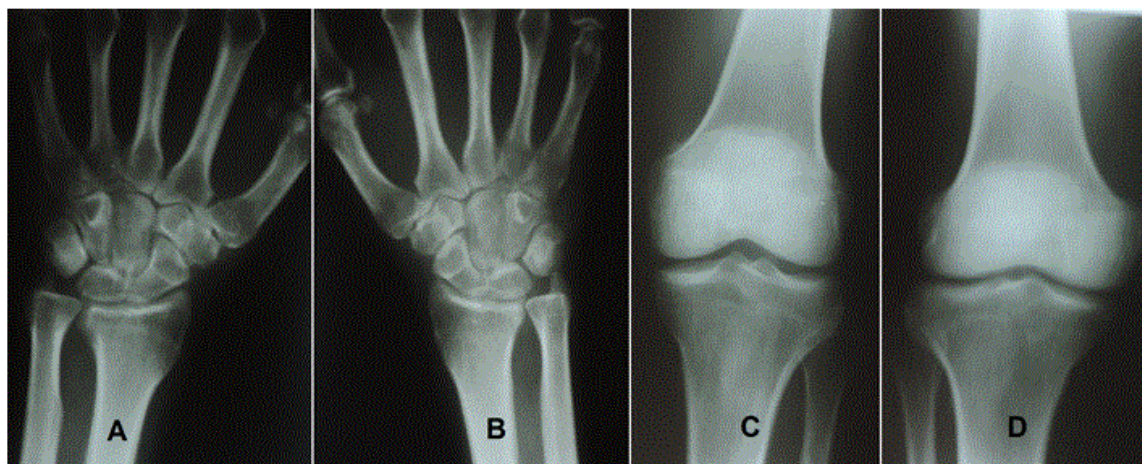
X-rays showing mild sclerotic changes A,B) Left and right wrist joint respectively C,D) Left and right knee joints respectively
